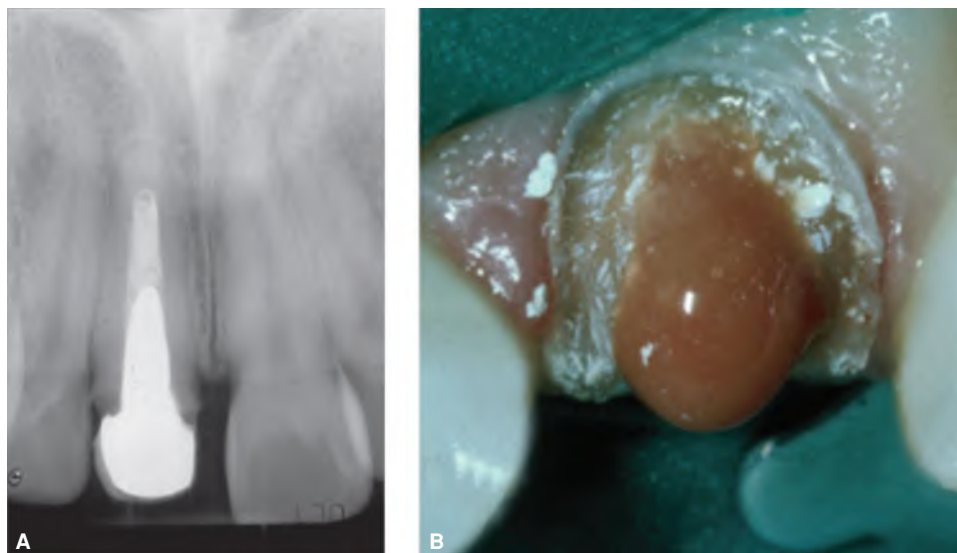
The maxillary right central incisor has a root-filled and infected root canal system and a primary acute apical abscess as a result of breakdown of the crown restoration. A. Periapical radiograph showing no periapical changes. B. Pus draining as soon as the existing root canal filling was removed.
